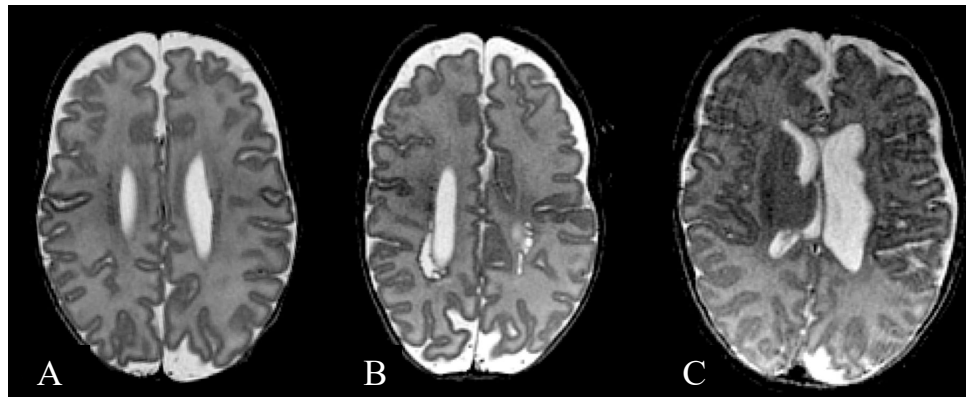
Transverse T2-weighted images at term-equivalent age showing (A) punctate white matter lesions, (B) periventricular leukomalacia, and (C) haemorrhagic parenchymal infarction.
